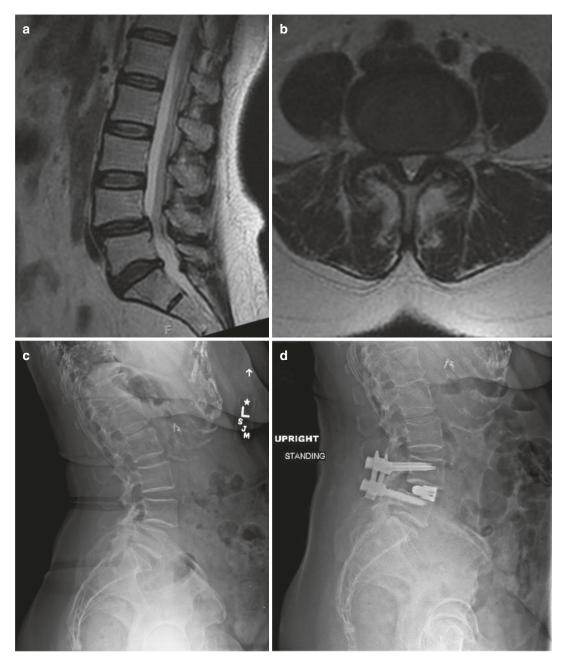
Case example of a patient suffering from lumbosacral double crush syndrome. This patient is a 65-yearold male who presented with symptoms of bilateral L5 radiculopathy, left worse than right, with weakness in ankle dorsiflexion and eversion on the left. An MRI of the lumbar spine demonstrated grade 1 anterolisthesis of L4 on L5, with severe bilateral neuroforaminal stenosis (a, b). Because of this, he was offered an L4–L5 minimally invasive transforaminal lumbar interbody fusion, which he tolerated well, leaving the hospital POD 1 with notable relief of symptoms (c, d). At his 6-week postoperative visit, his radiating back pain was resolved but he continued to complain of pain and paresthesias in the dorsum of the foot and had little improvement in his foot drop on the left. Electrodiagnostic studies were obtained and were consistent with a mild-to-moderate peroneal neuropathy that localized to the fibular head. We offered him decompression, with exposure of the nerve shown in (e), and release of several compressive bands, including the leading edge of the peroneus longus (arrowheads) (f)
